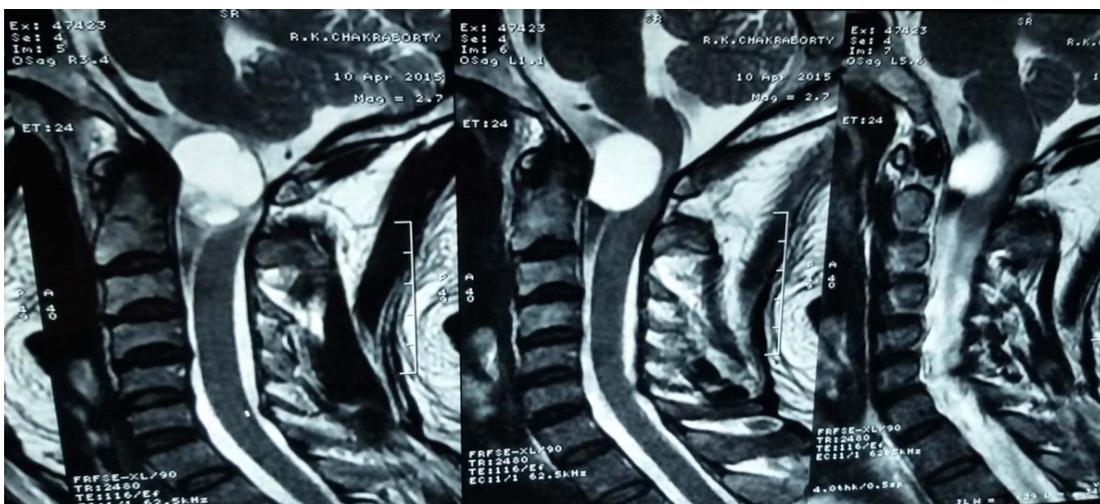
Pre-op sagittal T2-MRI
